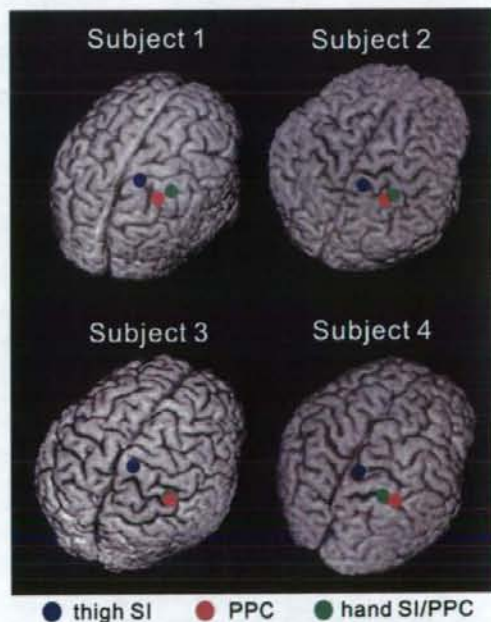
Results of ECD analysis for the thigh SI, PPC, and hand SI/PPC in four representative subjects. The locations of ECDs are superimposed on own subject's 3D-MRI. Blue and red circles indicate the ECD locations of the thigh SI and PPC, respectively. Green circle shows the ECD location of the hand SI/PPC.
